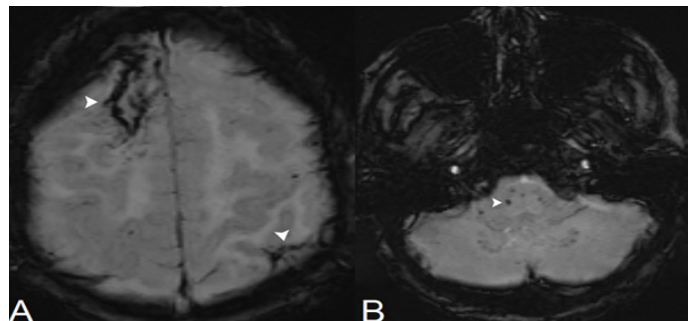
Brain MRI. Axial SWI images. A. Hypointense signal changes indicating hemorrhage in the right frontal and the left parietal lobes (arrowheads). B. Dot-like hypointense signal changes suggesting microbleeds in the brainstem surface (arrowheads).
